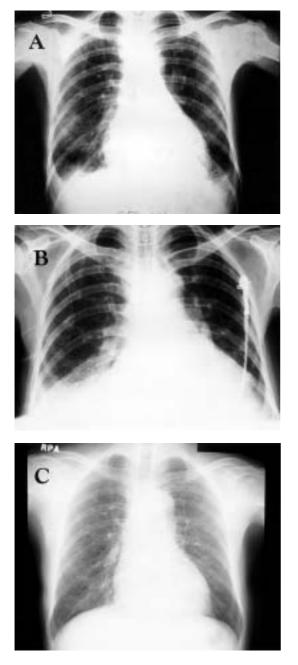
Posteroanterior chest radiographs
